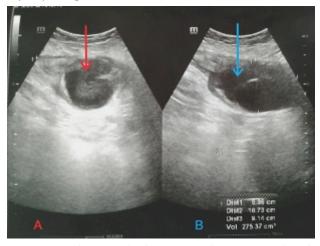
Ultrasound showing Right Rectus Sheath Hematoma (Arrows)
